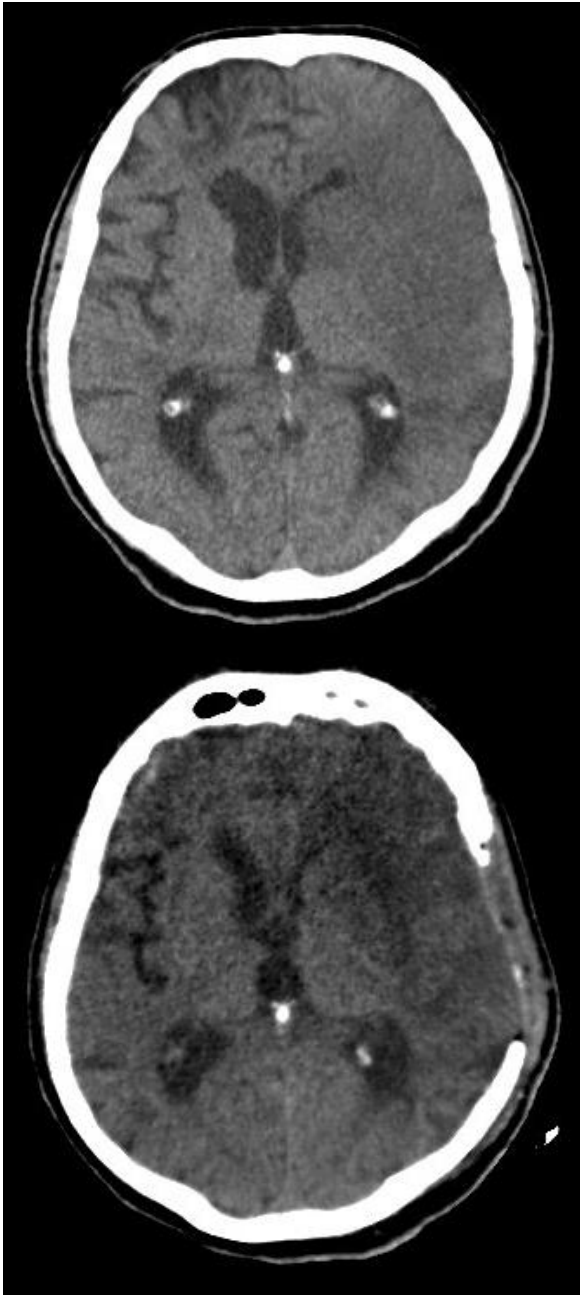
Pre and post-surgery CT images of patient received decompressive hemicraniectomy due to left middle cerebral artery infarction.
